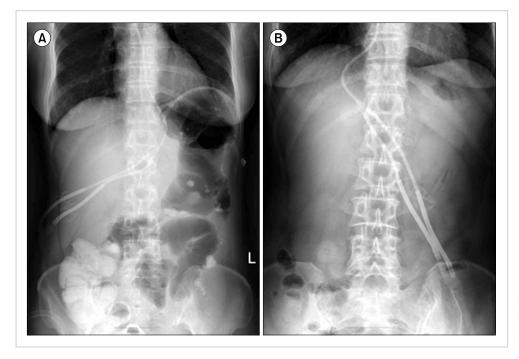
Follow-up plain abdominal radiographs obtained on day +24, when neostigmine administration was initiated (A), and on day +30 show complete resolution of the colonic dilatation (B).
